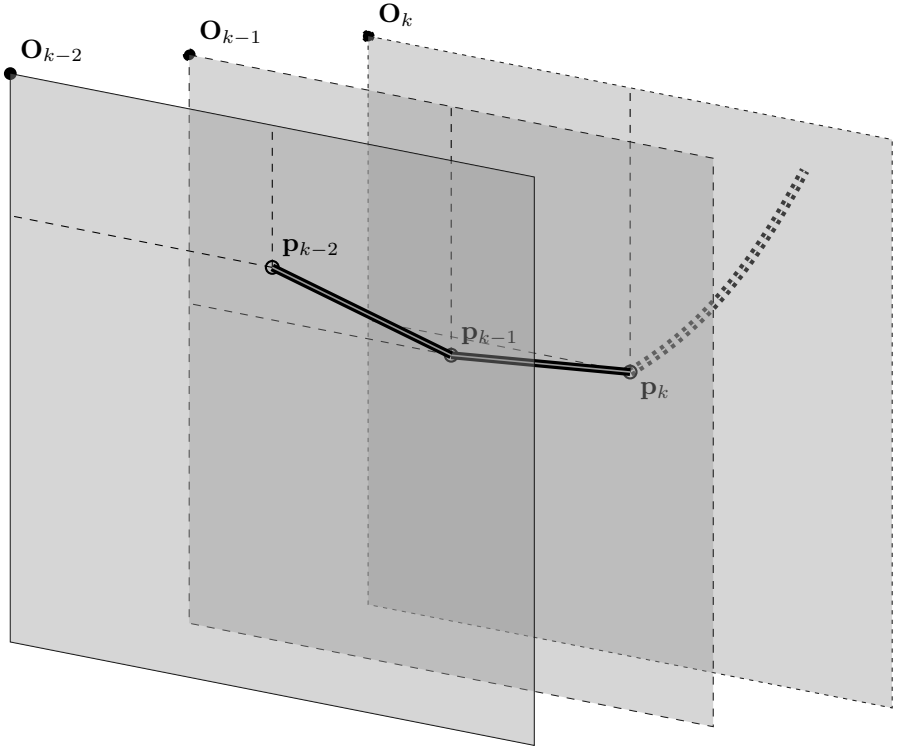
Plane positions depicted at several time points (k). We are assuming that the tracked ultrasound image plane is moved over the catheter obtaining short axis slices of the catheter. If the image plane orientation and position are known the intersection points (\mathbf{p}) of the catheter with the image plane can be estimated as well as measured by tracking the catheter intersection in the ultrasound image itself.
